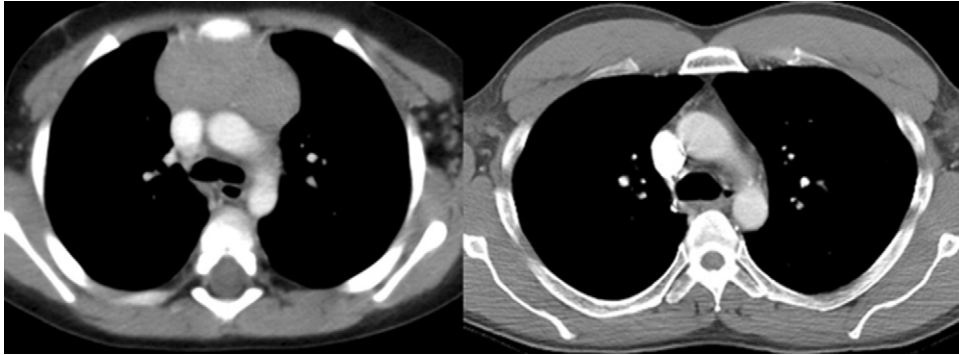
Representative axial unenhanced CT images show normal prominent oval soft-tissue attenuation thymus in anterior mediastinum of 6-year-old boy and diffuse fatty atrophy of thymus with triangular anterior mediastinal fat remaining in 40-year-old man.
